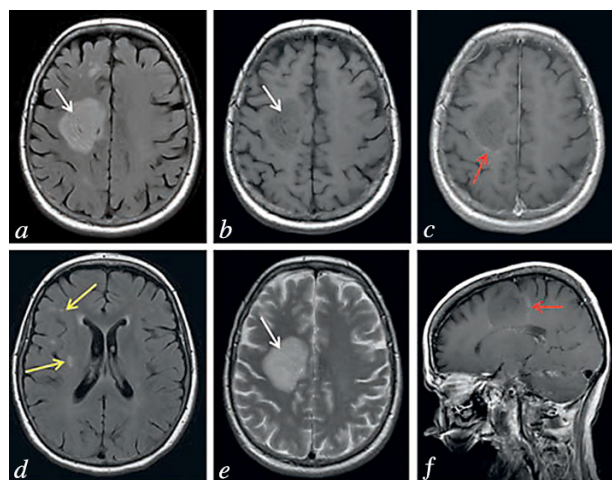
MRI brain scan with contrast, October 14, 2015, T2 FLAIR (a, d), T2 (e), T1 (b) modes, axial projection, and T1 mode after administration of contrast medium, axial projection (c) and sagittal projection (f). The white matter of the frontal lobe of the right hemisphere of the brain contains a round zone with smooth, clear edges and heterogeneous structure – alternating annular zones reminiscent of annual growth rings in tree trunks (white arrows). Administration of contrast medium was followed by partial accumulation of medium at the periphery of the zone (red arrows). In addition, the white matter of both hemispheres of the brain contains numerous plaques whose origin needs to be differentiated between vascular and demyelinating processes (yellow arrows).
